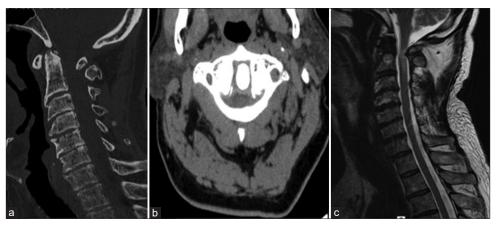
CT scan (image a and b) reveals stenosis of the canal at the level of the first cervical vertebra, with no fissures along the entire extension of the posterior arch of CMRI (image c) reveals compression in the cervical segment of the spinal cord.
